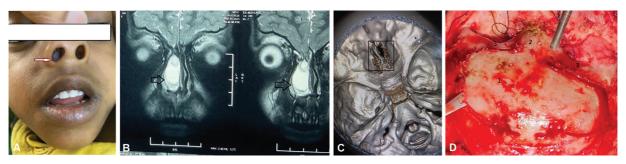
(A) The nasal component of the encephalocele appears like a globular mass visible inside the Rt nasal cavity. (B) MRI brain showing a trans-ethmoid trans-nasal encephalocele. (C) CT brain which was suggestive of a defect in the ant skull base. (D) Craniotomy and repair of the defect (1) Frontal bone (2) Nasal bone (3) Supraorbital ridge.
